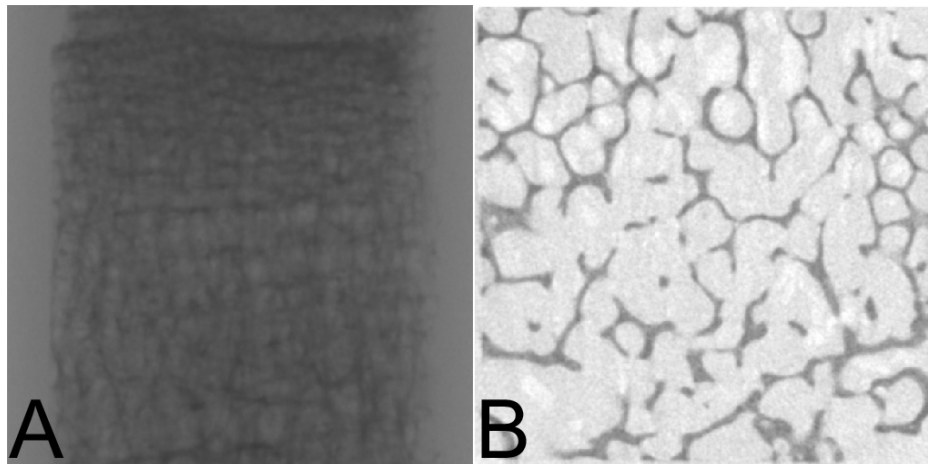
Examples of (A) shadow projection and (B) reconstructed tomographic image from μ CT.
